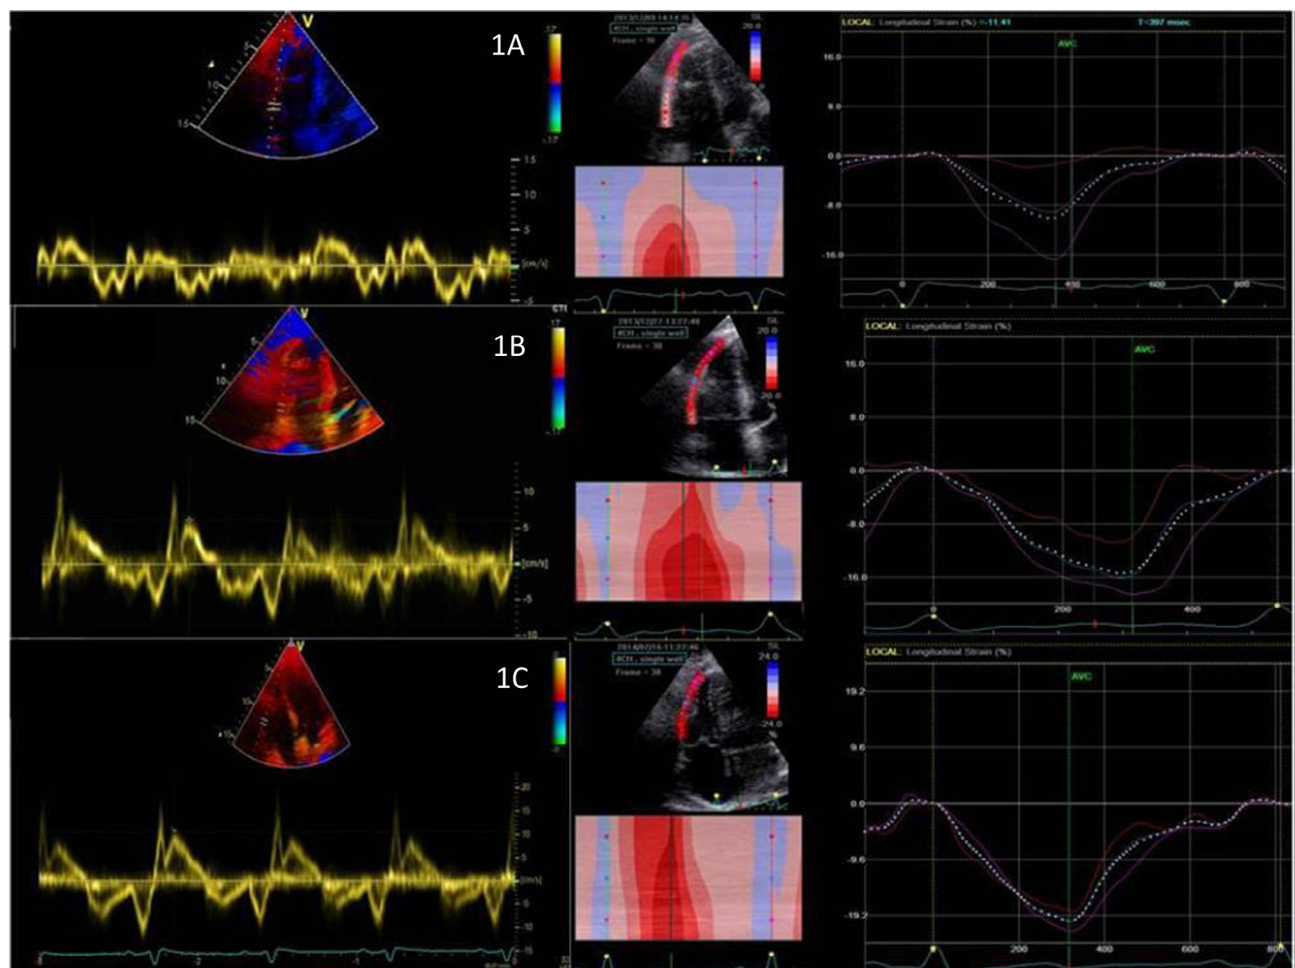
(A) Tissue Doppler of tricuspid annulus and right ventricular strain imaging of Patient 1 at the time of diagnosis showing very low myocardial velocities. (B) Tissue Doppler of tricuspid annulus and right ventricular strain imaging of Patient 1 at the end of the first chemotherapy cycle showing improvement of myocardial velocities. (C) Tissue Doppler of tricuspid annulus and right ventricular strain imaging of Patient 1 at the end of chemotherapy treatment showing normalization of myocardial velocities.
